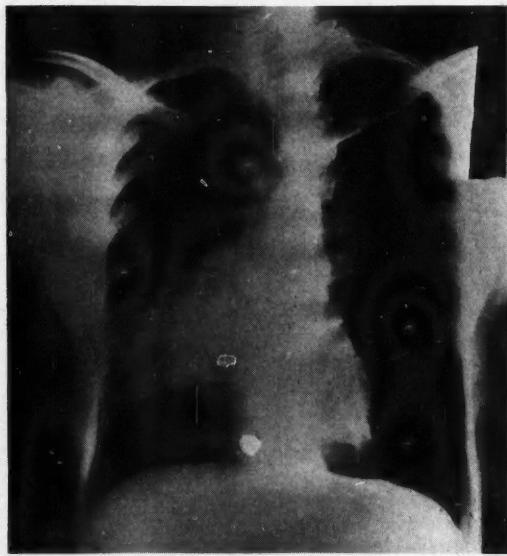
In x-ray film made November 27, 1950, clearing of the consolidation at the right base was noted.
